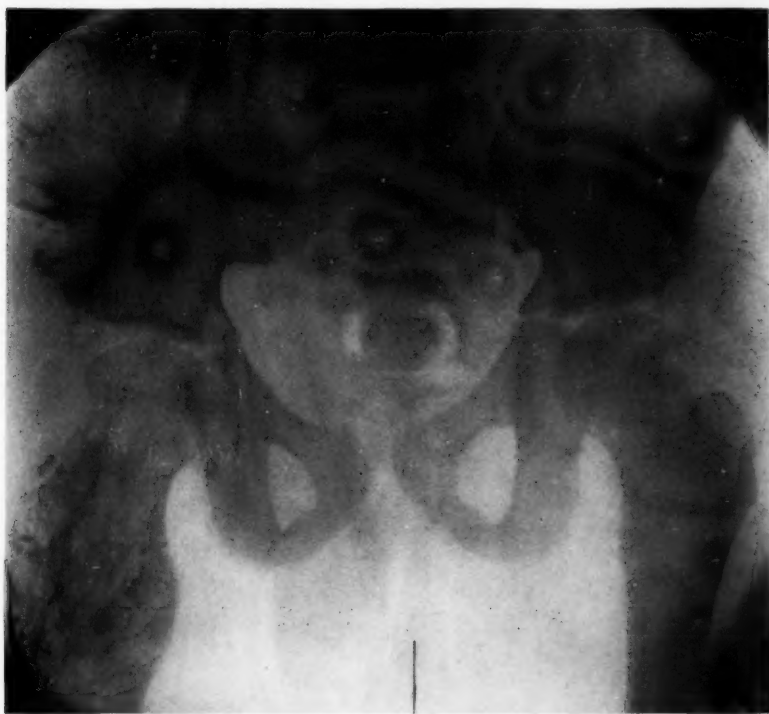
Case I. X-ray showing extensive pathologic change of left ilium and upper end of left femur.
